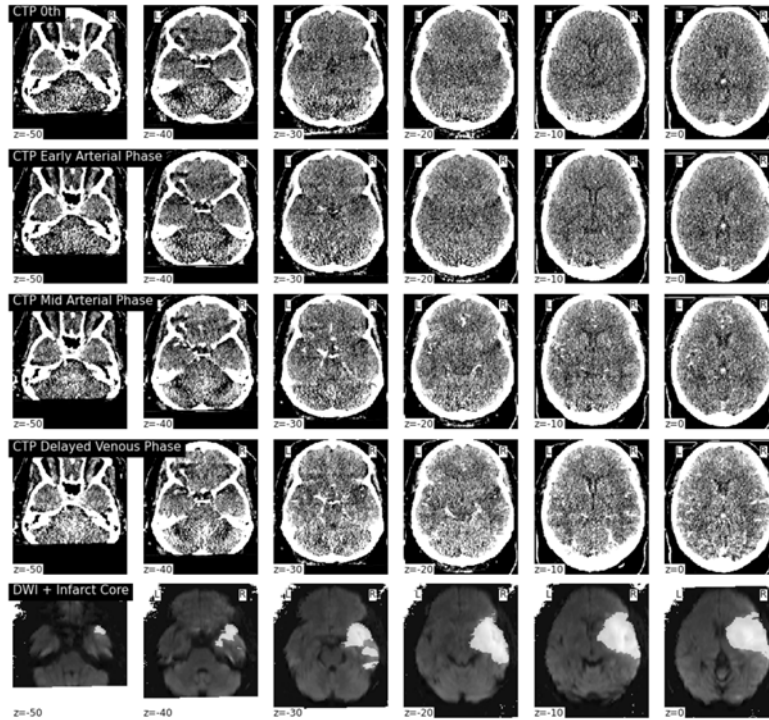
Axial slices of 4 different instances of time of the CTP (4 first rows: 0th time, early arterial phase, mid arterial phase and delayed venous phase) and axial slices of the MRI DWI with the manual segmentation overlaid in white (last 5th row) of one patient of the dataset. Images are aligned to the MNI space.
